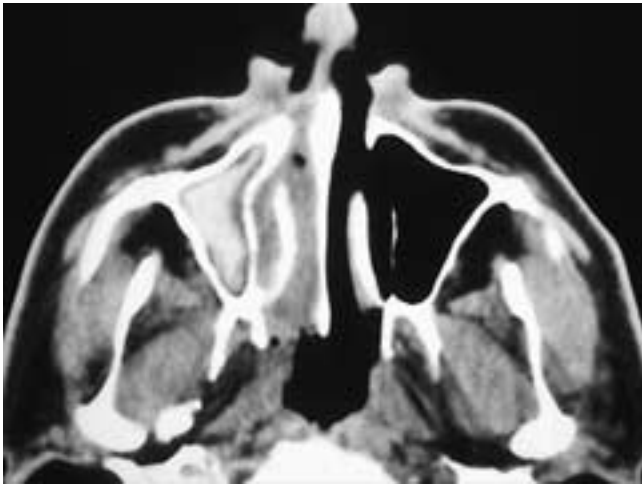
Axial CT scan shows high-attenuation material within the right maxillary sinus, separated from the sinus bony wall by a thin zone of water attenuation. The most common cause of this CT appearance is desiccated secretions. A mycetoma in fungal sinusitis and intrasinus hemorrhage also can have this appearance. This patient had chronic sinusitis.
